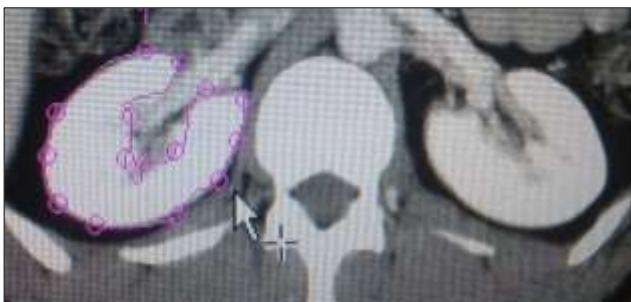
Method 1- Intra venous contrast enhanced CT axial sections of the abdomen at the level of the kidneys demonstrating manually corrected region of interest drawn on the right kidney as in Relative renal volume method. Note that the ROI includes normal enhancing renal parenchyma and excludes hilar fat and blood vessels.
